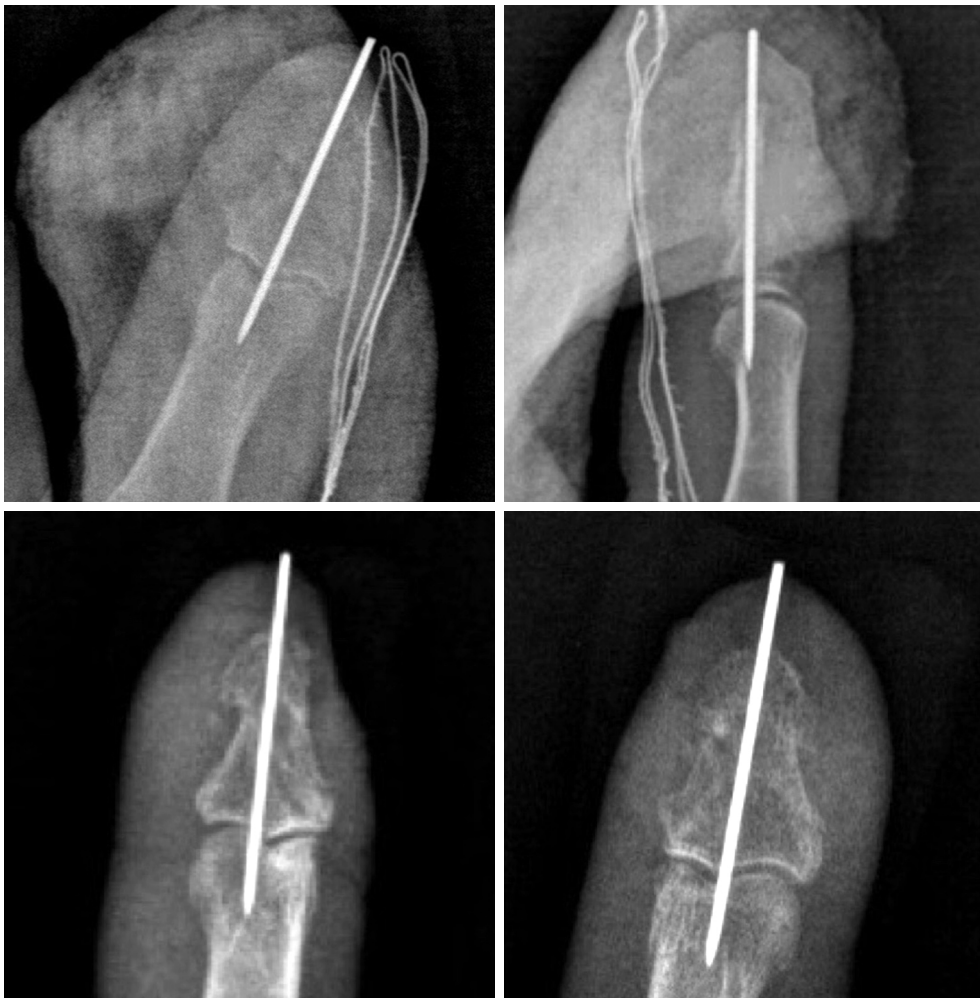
Postoperative and Week 6 X-ray of the left thumb.
